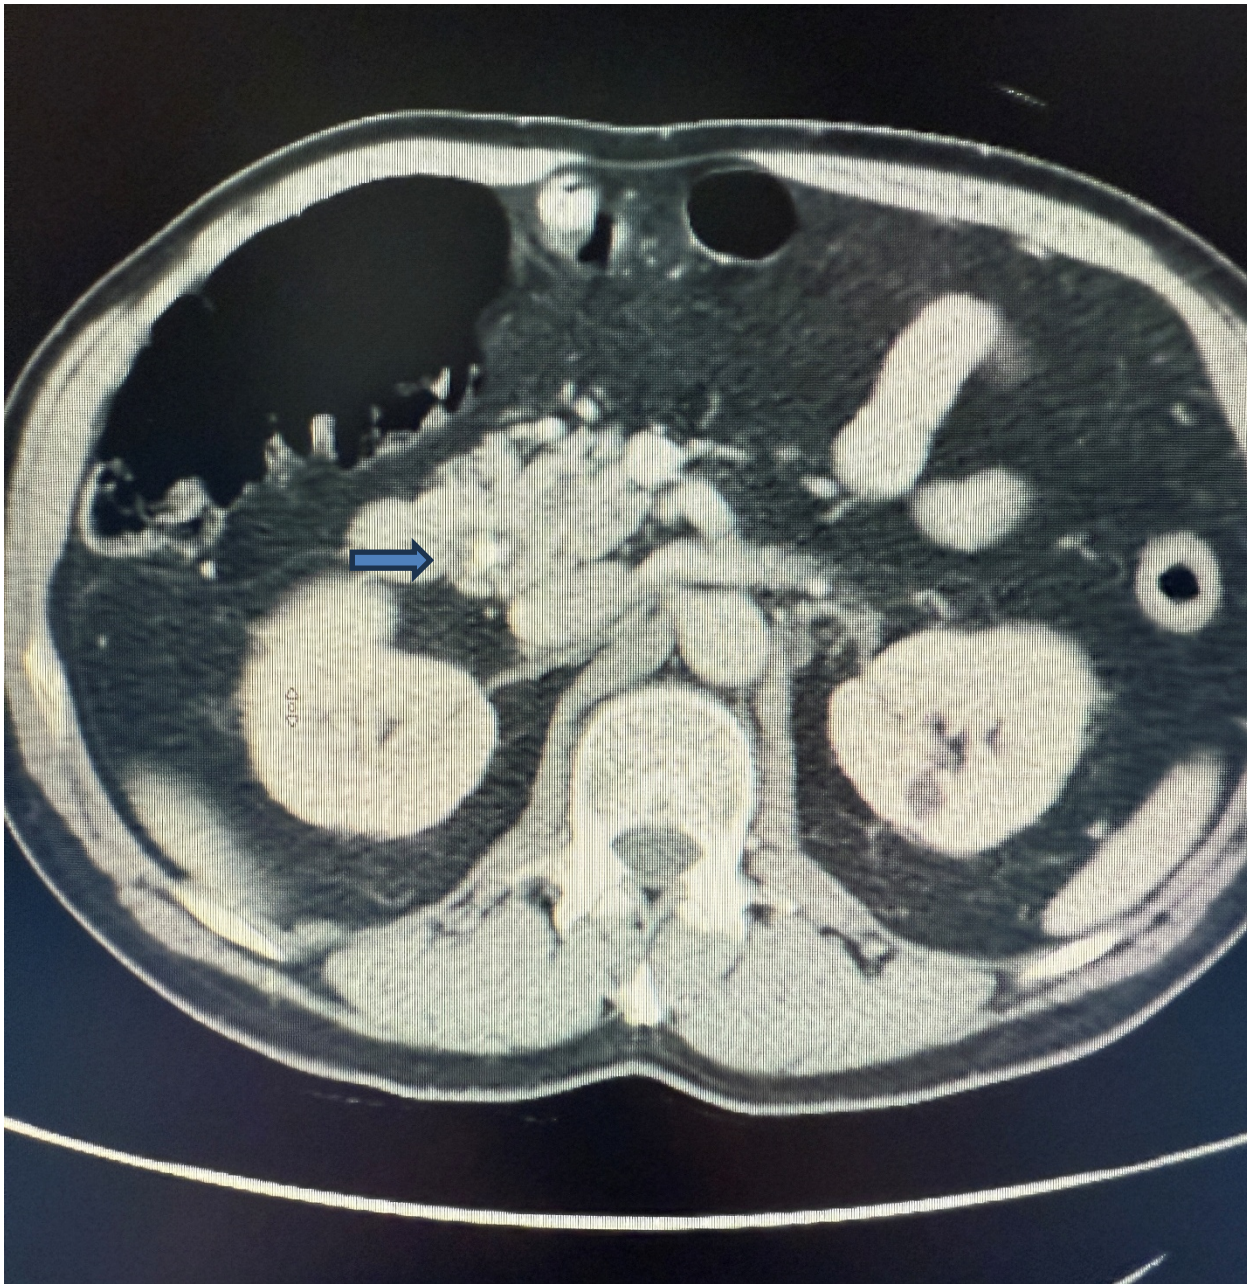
CT scan image green arrow showing dilated bile duct with bile duct stone
